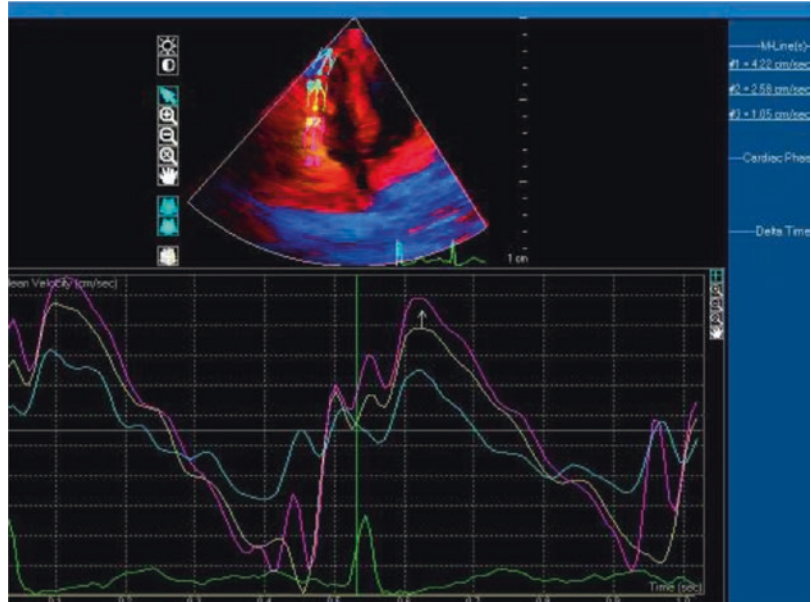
Color tissue Doppler. The systolic longitudinal shortening velocities of the different segments of the RV free wall, including the basal ones, are normal in a patient with SSs (white arrow). Personal case
